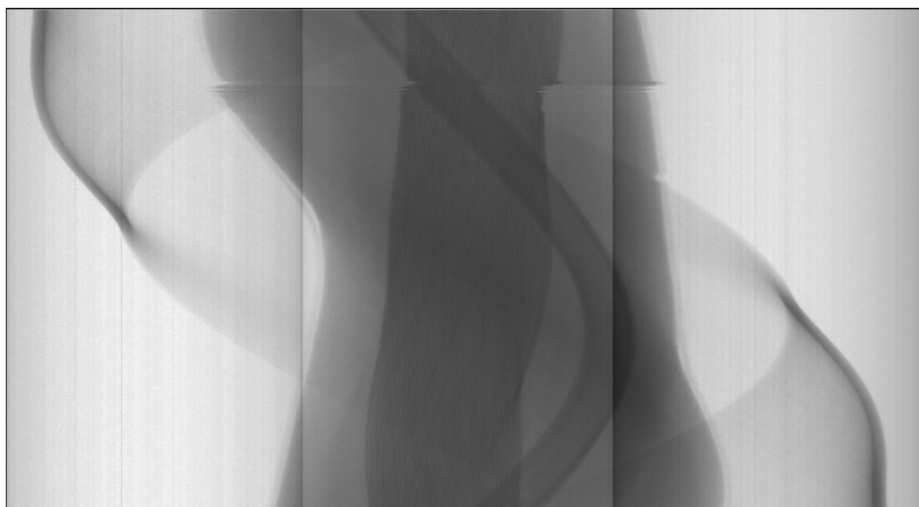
An example sinogram from a slice of a tibial HRpQCT scan with motion artefact. Each row of the scan represents an angle where X-rays were passed through the subject. The pixels in each row show the projection created by a plane of X-rays passing through the subject's leg at a given angle. Here a clear jump can be seen roughly a quarter of the way down the scan, this represents where the subject has moved and their leg is now in a different location. This jump is the cause of the motion artefact seen in Figure 2.
